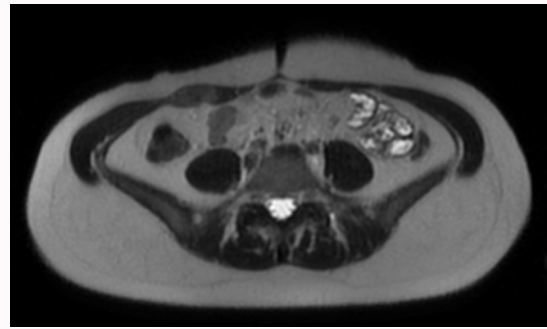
MRI (T2 image) with tumor in M. rectus abdominis of the right side.
